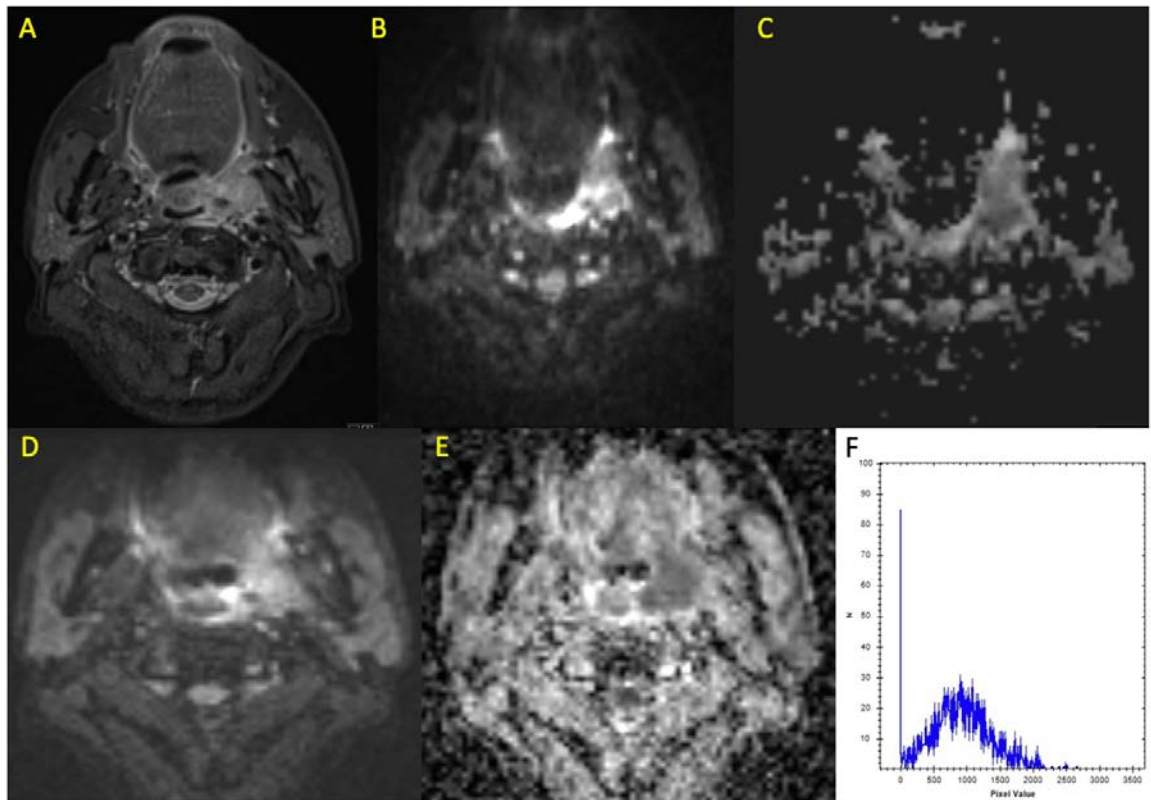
Diagnostic DW-MRI sequences.
